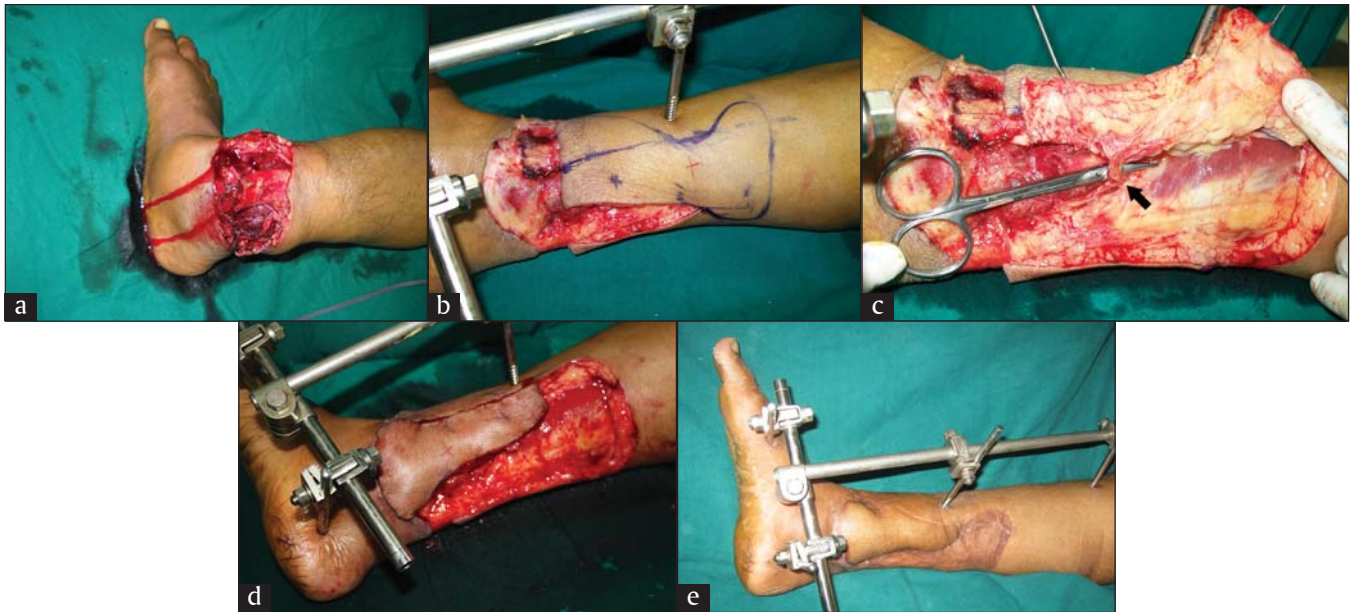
(a) A major crush injury of the lower third of the leg, (b) the defect after debridement and the Doppler examination showed good audible signals at X, and a flap marked, (c) the proposed flap elevated on one side and the perforator visualized before the whole flap is raised, (d) the flap raised and rotated through 180 degrees to cover the critical area and (e) a well-settled flap and the healed donor area
